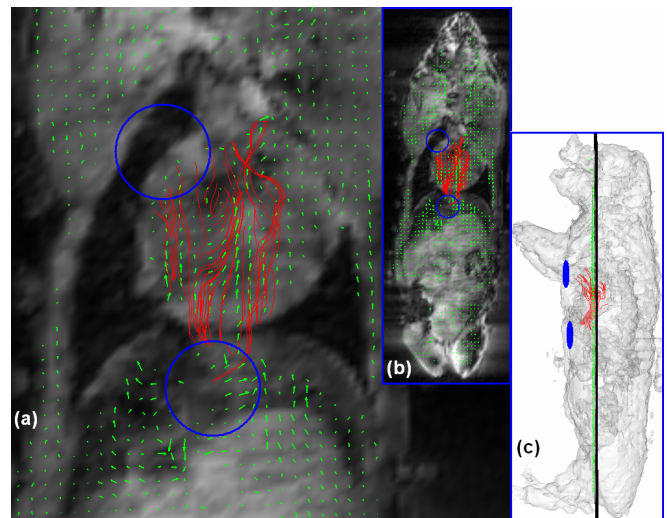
CDI vector plot shown as green arrows superimposed on structural anatomical MRI data. (a) Chest view showing heart, lungs and diaphragm at a cross-section shown by the black line in the left side view of (c). Blue circles indicate positions of electrodes on the chest. (b) Full body view of (a). (c) Left-side view.
